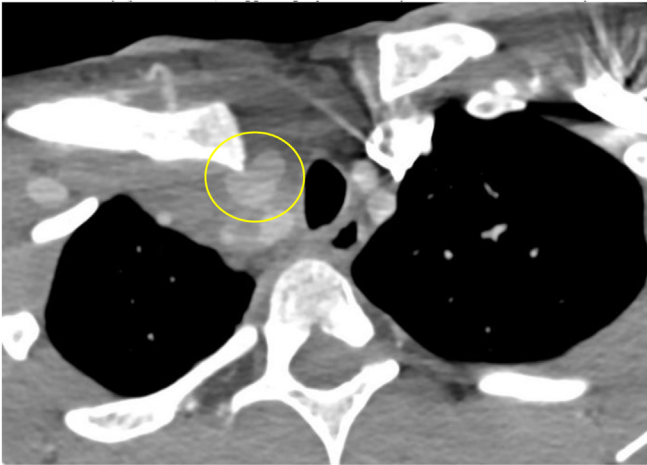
Computed tomography angiogram showing a 1.8-cm maximum diameter amorphous hyperdensity abutting the anterior aspect of the innominate artery (yellow circle), suggesting a pseudoaneurysm of the innominate artery.
